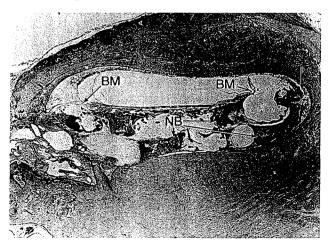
Basal turn near cochleostomy site of case 7, in which there was no radiographic or clinical evidence of new bone formation before operation (original ×18.5). Scala tympani contains new bone (NB). There is trauma to basilar membrane (BM) and to spiral ligament (SL), caused by electrode array.
